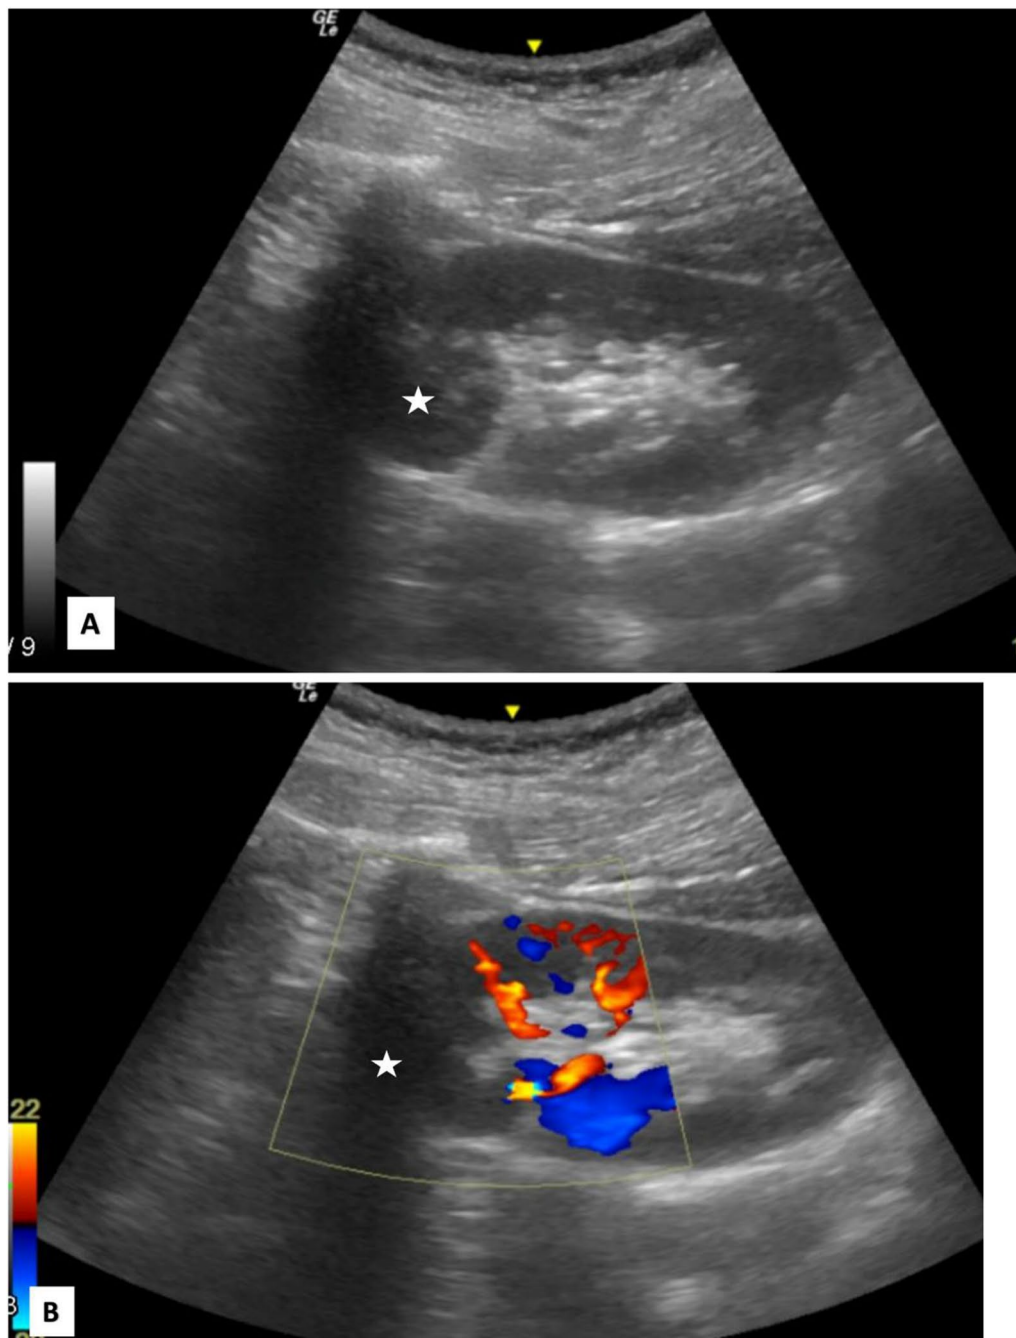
A Sagittal Gray Scale Sonography image of the left kidney shows an ill-defined hypoechoic mass (asterisk) in the upper pole causing compression and displacement of the renal sinus fat. B Colour Doppler image, using low frequency curvilinear transducer does not show any obvious vascularity of the mass lesion (asterisk) in the upper pole of the kidney
